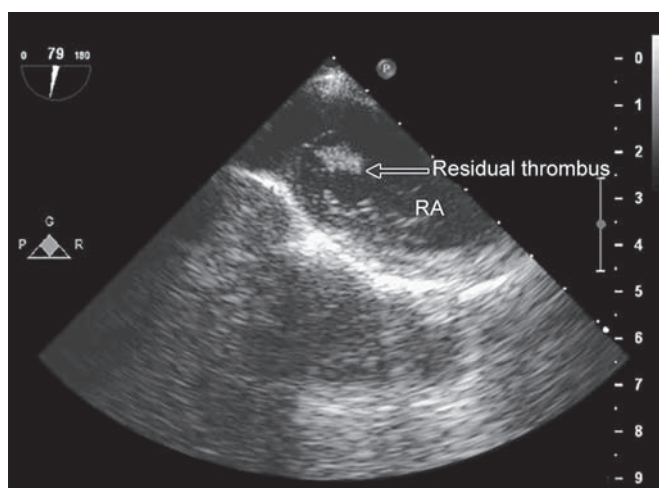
Transesophageal echocardiography showing residual tumor attached to pectinate muscle in right atrium
